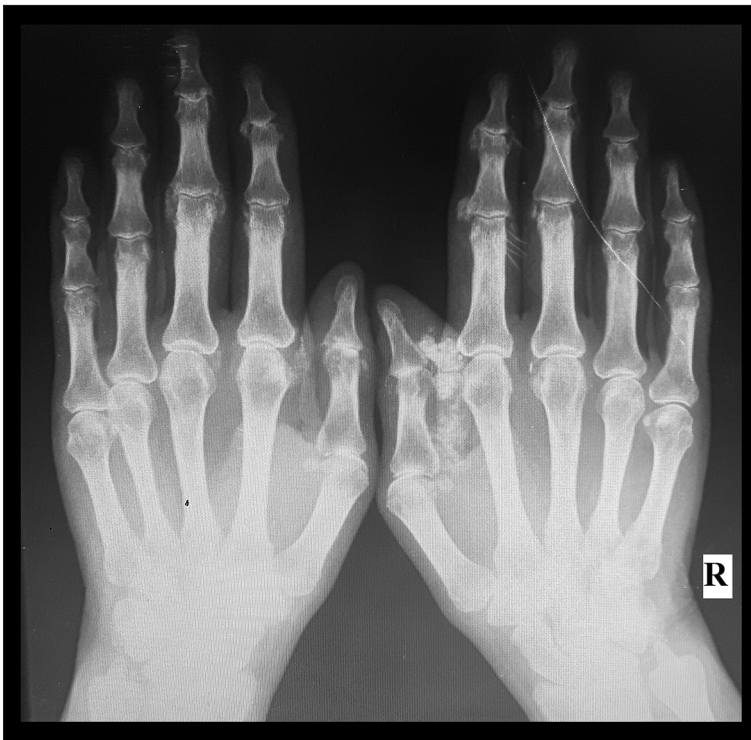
X-ray of hands with erosive arthritis and periarticular calcification.
